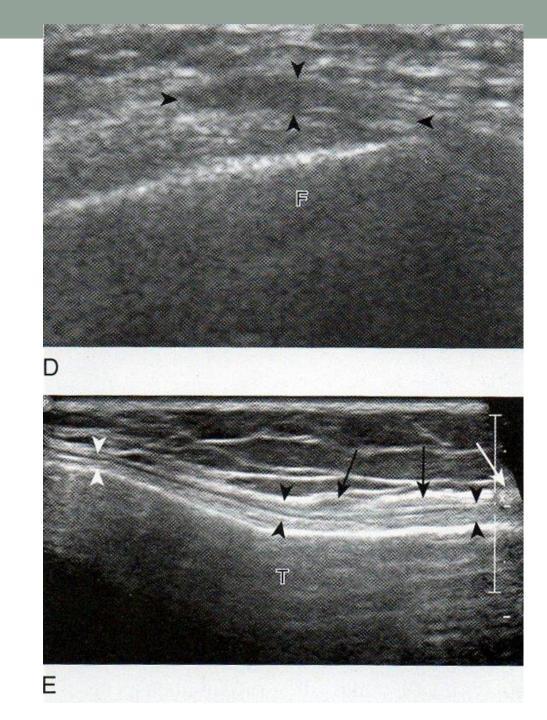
Medial collateral ligament injury. Ultrasoun images longitudinal to the medial collateral ligament in three different patients show (A) anechoic fluid (arrows) superficial the intact medial collateral ligament (arrowheads) (grade 1 injury), (B) full-thickness tear (arrows) (grade 3 injury), and (C) hypoechoic thickening of the proximal medial collateral 1 ment (arrows) from remote injury with normal distal ligamer (arrowheads) (F, femur; M, medial meniscus body; T, tibia).
